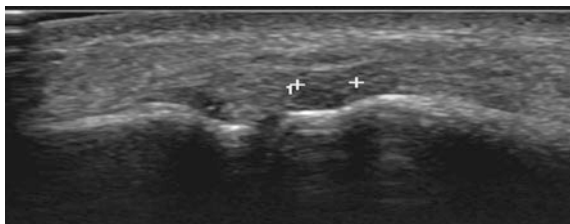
Longitudinal ultrasound image showing rupture of radial collateral ligament
